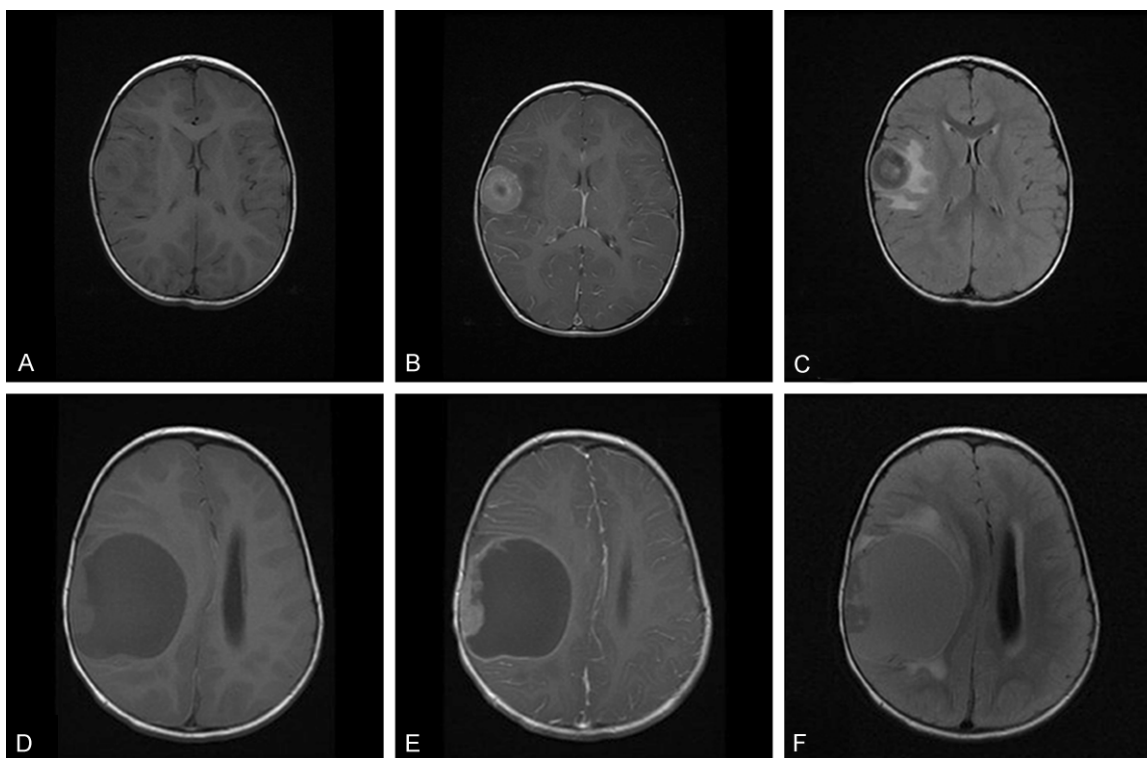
The tumor of Case 1 appears as a well demarcated right frontal lobe mass which is slightly hyperintense to grey matter and slightly hypointense to white matter on non-contrast T1 weighted imaging (A). The lesion enhanced with contrast (B). A centrally located necrotic nidus is present. FLAIR imaging demonstrates a moderate amount of edema around the tumor (C). The tumor of case 2 appears as a well demarcated primarily cystic lesion (D) causing midline shift. It has a mural nodule that is isointense to grey matter and hypointense to white matter. Enhancement of the solid component is present (E). FLAIR imaging demonstrates a moderate amount of edema around the tumor (F).
